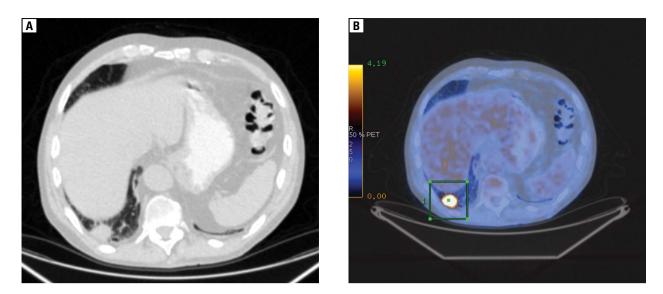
Malignant mass localised in the right lung shows high 18F-FDG uptake on PET-CT image Rycina 1. Zmiana ogniskowa w płucu prawym o charakterze złośliwym i wysokim gromadzeniu znacznika w PET-CT
